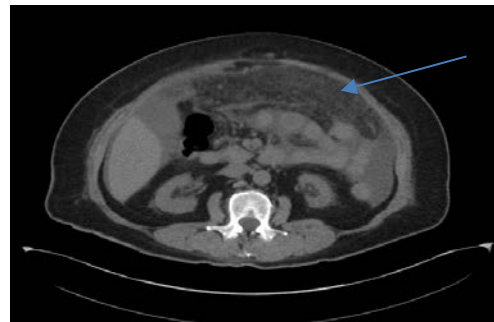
CT of the abdomen and pelvis showed increased density diffusely throughout the omental fat in the mid abdomen which is consistent with inflammatory changes (arrow).
